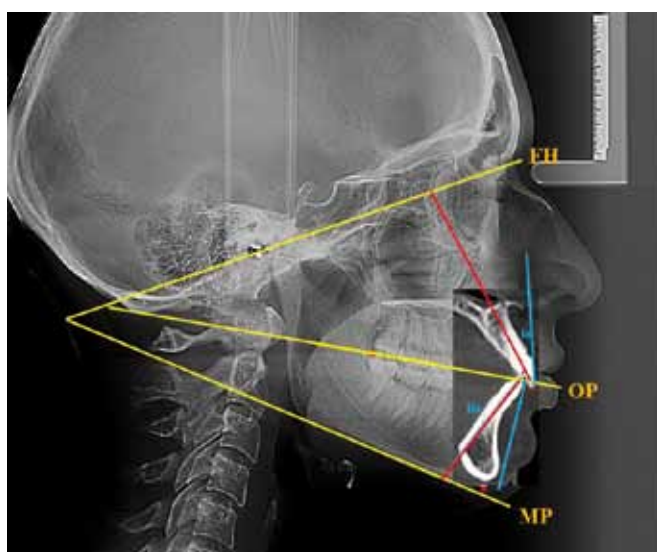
The combination of teleroenogram and cone-beam tomogram with marked reference lines
